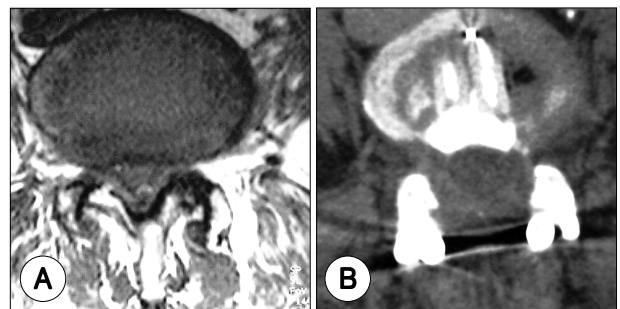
A : preoperative transaxial L4-5 magnetic resonance T1WI shows hypertrophied ligamentum flavum and facet joints. B : Postoperative transaxial L4-5 computed tomography scan shows total laminectomy, medial facetectomy and pedicle screw.
